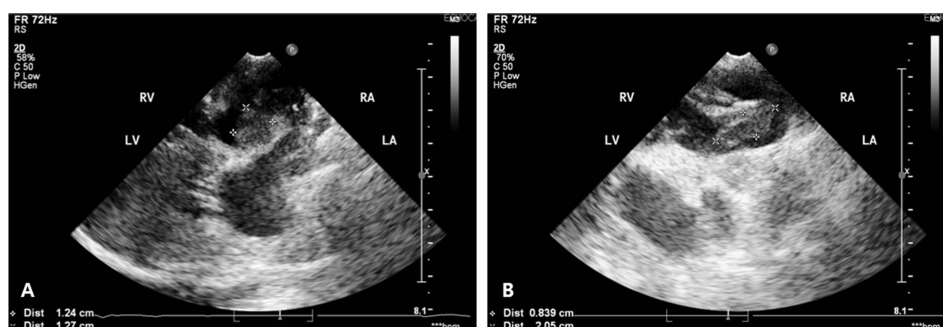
Echocardiography of the patient after rtPA treatment (A, B). There was no change of atrial thrombus size.
